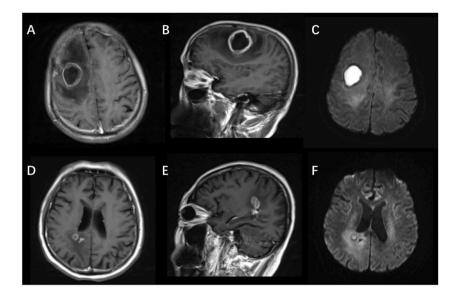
Example of preoperative magnetic resonance imaging of brain abscess caused by *Streptococcus* species (A–C) and *Nocardia* farcinica (D–F). (A–B) contrast-enhanced T1-weighted image shows a hypointense necrotic center with pus, ring-shaped enhancement of the abscess wall, and a hypointense zone of oedema surrounding the abscess. (C) Diffusion-weighted image shows a hyperintense signal within the abscess. (D–F) contrast-enhanced T1WI and DWI show multiple abscesses due to *Nocadia* farcinica.
